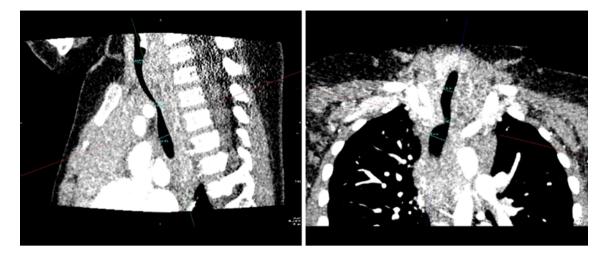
CT scan showing tracheal stenosis from posterior mediastinal mass and innominate artery syndrome
